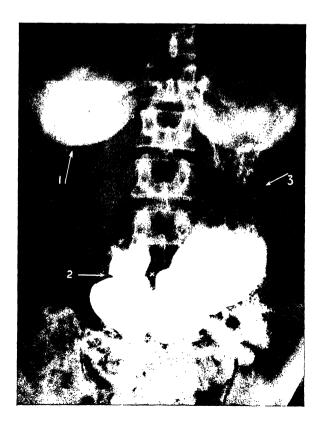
Radiograph of an atonic stomach after a barium meal. Note that this stomach contains the same amount of barium as the stomach in fig. 1. Arrow 1 points to the shadow of the right breast; arrow 2, to the pylorus; arrow 3, to the upper part of the body of the stomach, where longitudinal folds can be seen in the mucous membrane. XX marks a wave of peristalsis.
